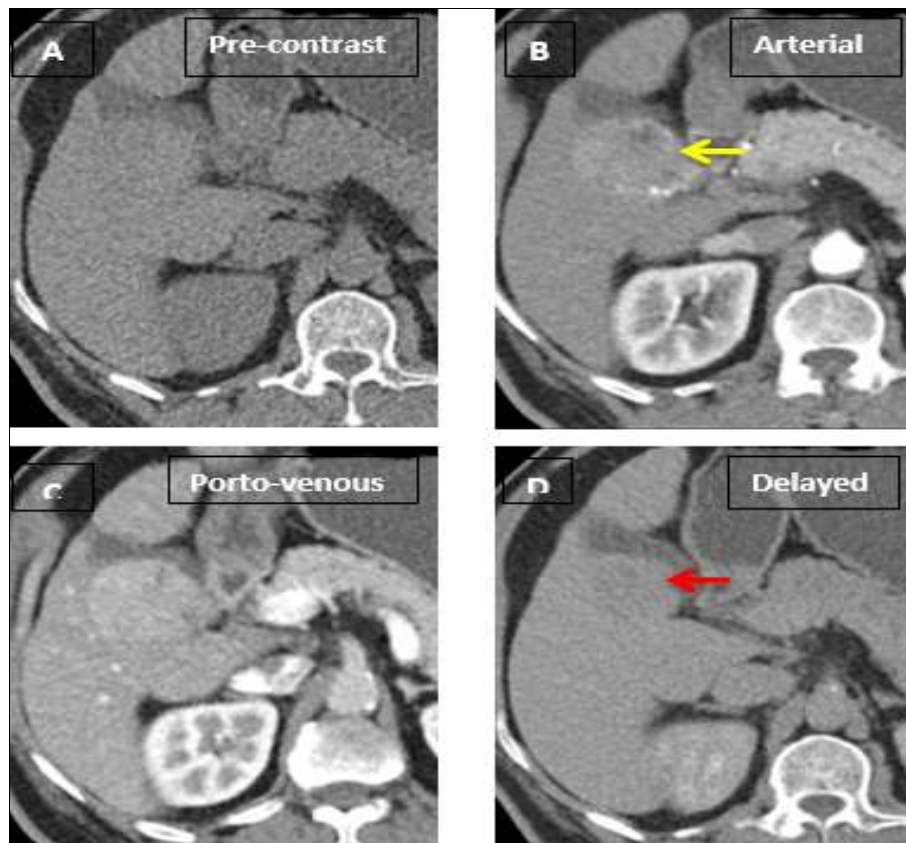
Axial CT images obtained before contrast administration (A) and after contrast administration at arterial phase (B), porto-venous phase (C) and delayed phase (D) revealed shrunken cirrhotic liver showing a 45-mm right hepatic lobe focal lesion at segment V showing hyper-enhancement at arterial phase (Yellow arrow) with enhancing capsule and washout at delayed phase (Red arrow)
